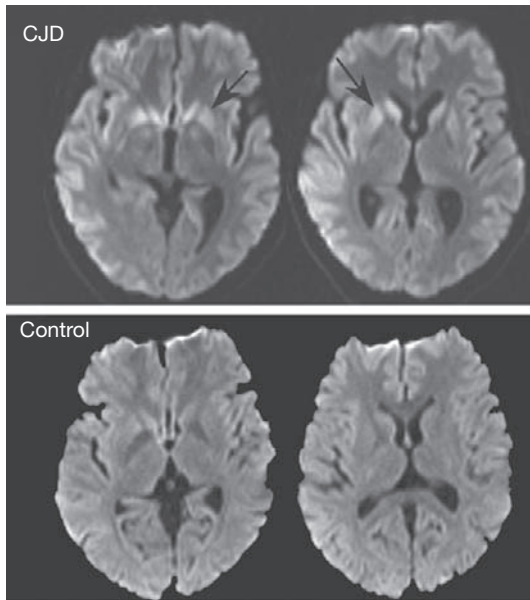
Creutzfeldt-Jakob disease. Images shown (FLAIR MRI) are from a 39-year-old woman who developed chorea, followed by anxiety and progressive cognitive and motor impairment, leading to inability to walk and marked dysarthria and dementia by the time this imaging study was obtained, that is, 5 months after symptom onset. Note the high intensity of the caudate and of the anterior portion of the lenticular nuclei (arrows). For comparison purposes, the lower image row was obtained with a similar technique, but from a control individual.
